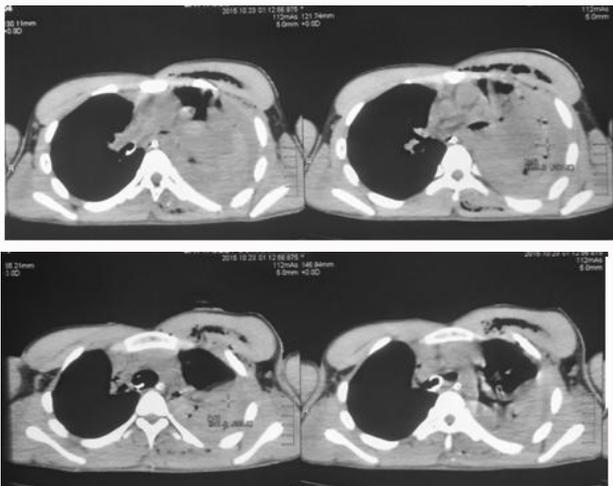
Shows CT scan chest with ET in right main bronchus, hemopneumothorax left lung (Day-1).
